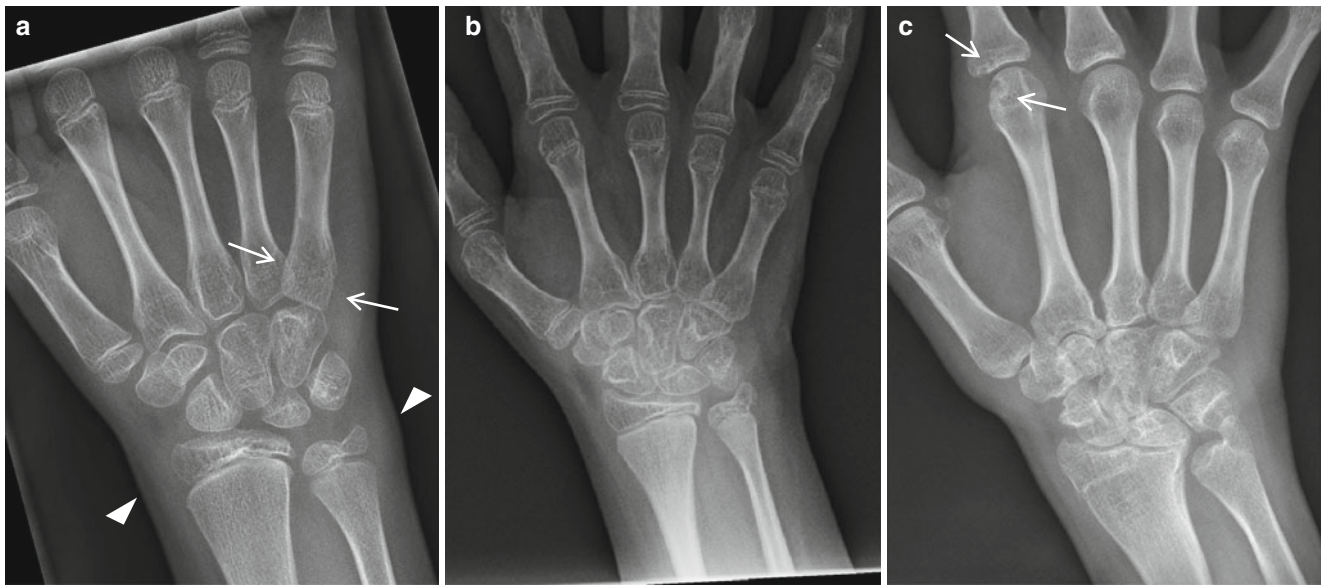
Juvenile idiopathic arthritis in different stages in different patients. (a) A 9-year-old girl with JIA. Wrist radiograph demonstrates periarticular osteopenia (white arrows) and soft tissue swelling (arrowheads). (b) An 11-year-old girl with JIA. Wrist radiograph demonstrates
